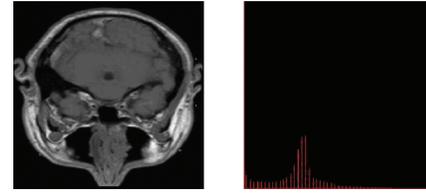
MRI scan and intensity histogram.
